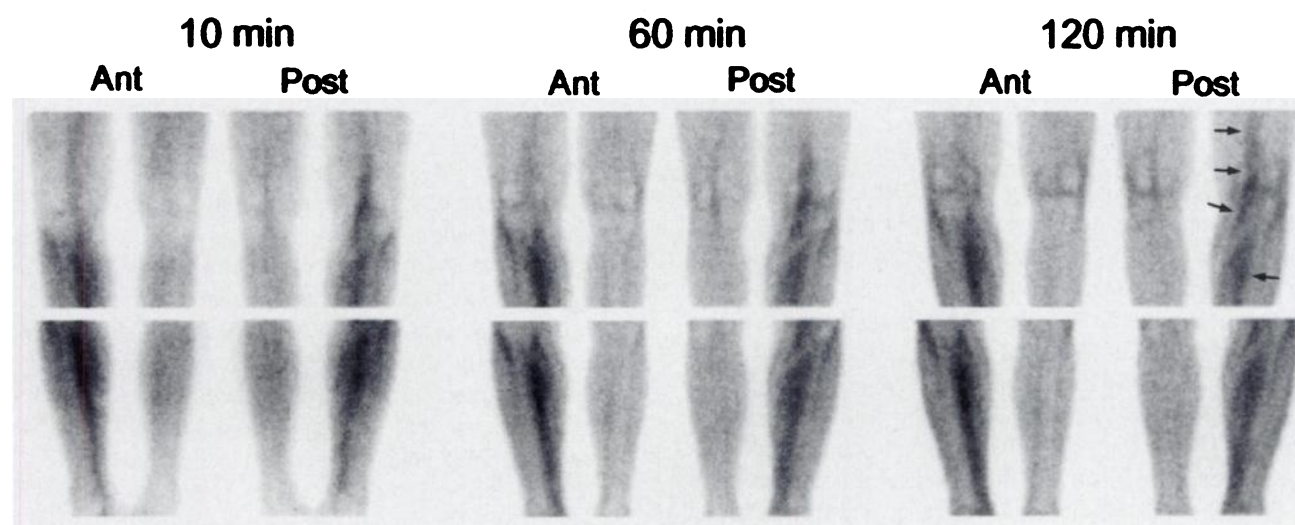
A 39-y-old man with no history of DVT who presented with pain, tenderness, and swelling of right calf of 2-d duration. Contrast venography showed thrombus in deep veins of right calf extending into popliteal vein. Ten-, 60-, and 120-min  $^{99m}\text{Tc}$ -apcitide scintigraphic images (anterior [Ant], left; posterior [Post], right) show acute DVT in right calf extending through knee to distal thigh.
